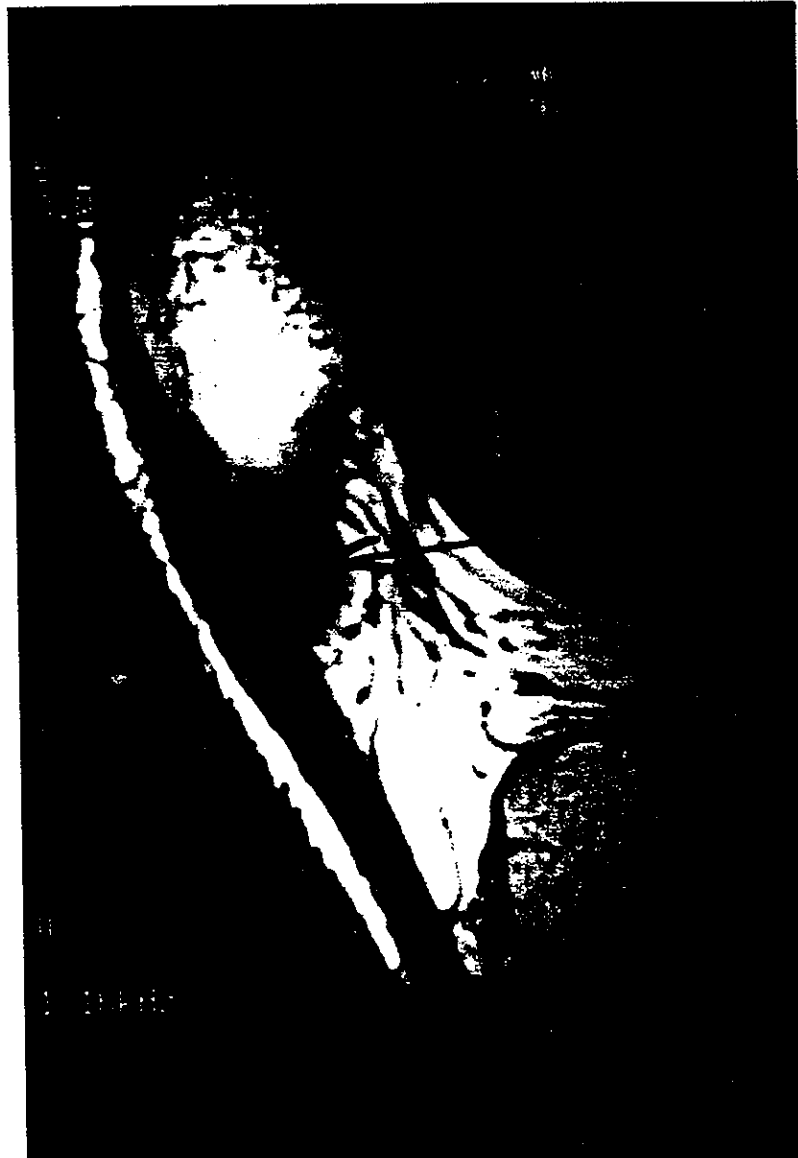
Sagittal MR images of an 18 year old man with jumper's knee.
